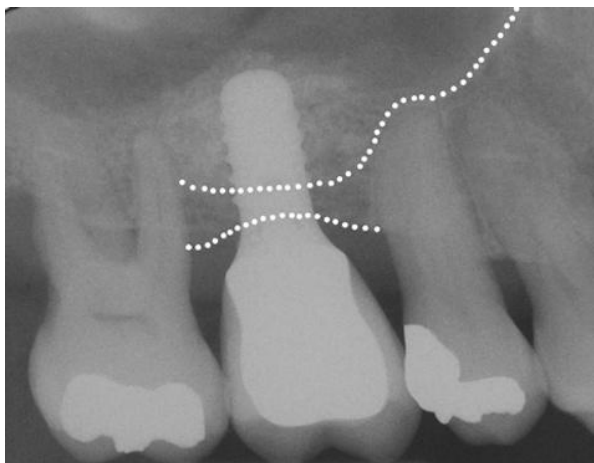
Radiograph of an implant inserted in the posterior maxilla with an oblique sinus floor and a residual bone height of 8–10 mm. The osteotome technique without grafting material was used. The distal aspect of the apex of the implant extends into the sinus cavity, but the mesial aspect is covered with residual bone.
